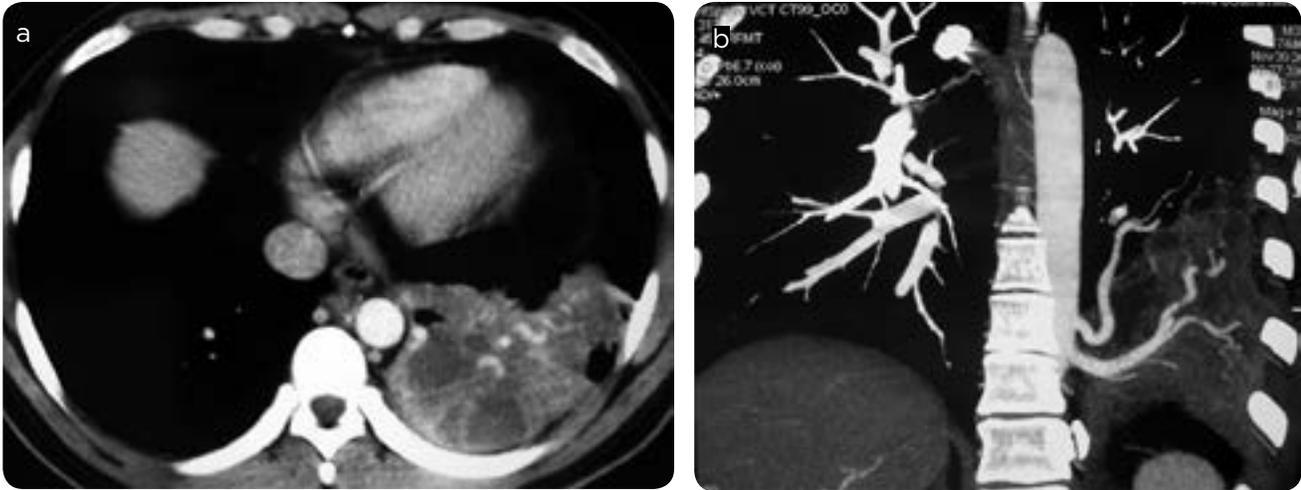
Pulmonary Sequestration. Child 4 years old. a and b) Chest CT, axial, in mediastinal window and coronal reconstruction MIP. Mass in left lower lobe of heterogeneous density with systemic irrigation.
